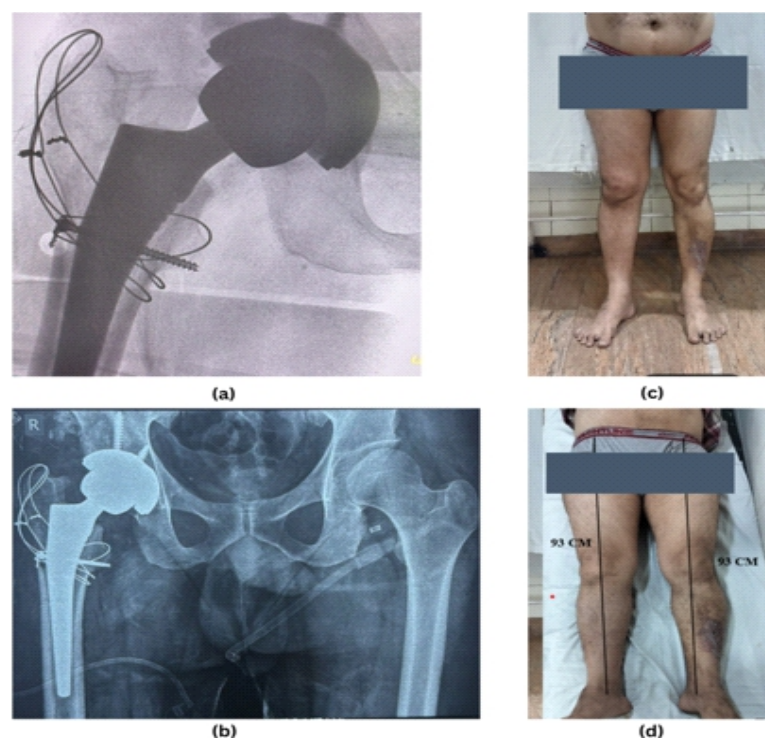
Post-operative radiological and clinical outcome. (a) Intraoperative fluoroscopic image demonstrating final implant position and fixation of the greater trochanteric osteotomy. (b) Post-operative anteroposterior radiograph of the pelvis showing a well-positioned total hip prosthesis with restoration of hip alignment. (c) Standing clinical photograph at follow-up showing improved posture and limb alignment. (d) Supine clinical photograph demonstrating restoration of equal limb length.
